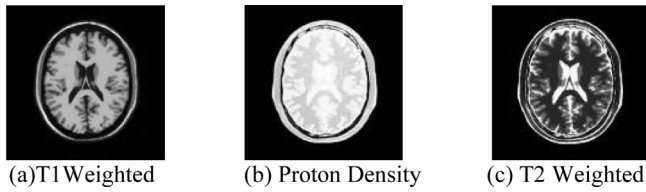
MRI Axial Scans.
